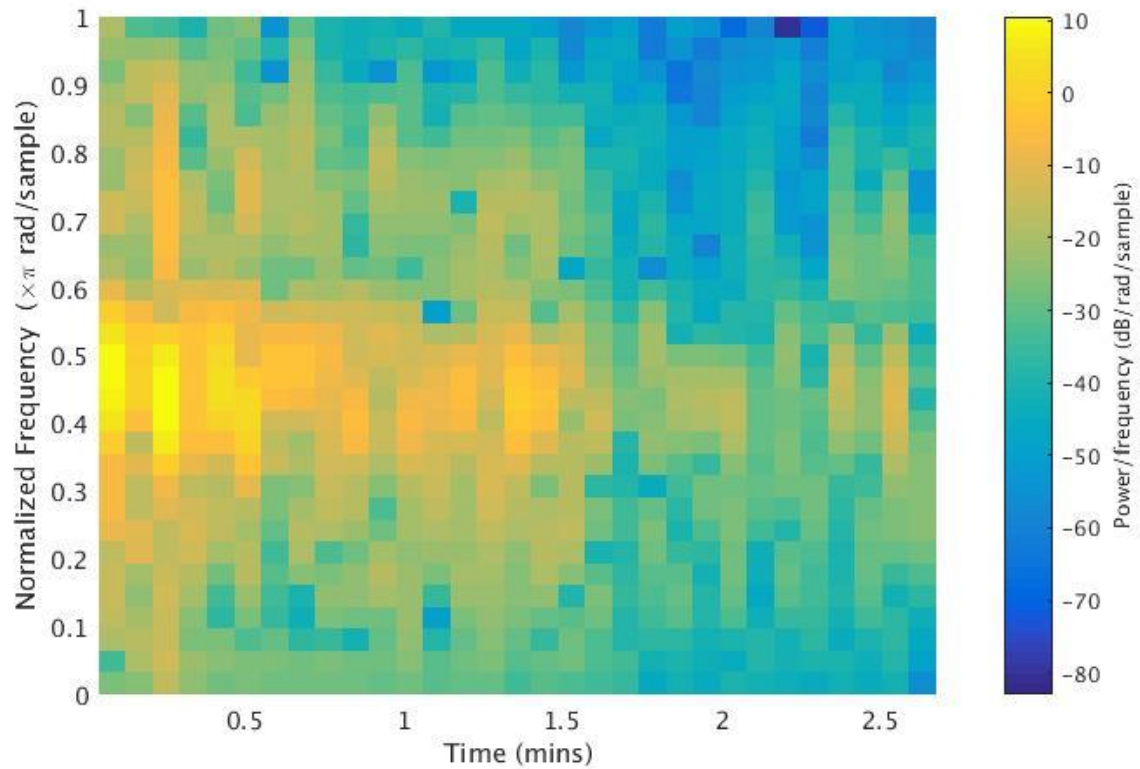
The spectrogram of one ultrasound RF signal from a fatty liver. The window used is rectangular window with length 32, the samples of overlap is 0 and the sampling points for compute discrete Fourier Transform is 62.
